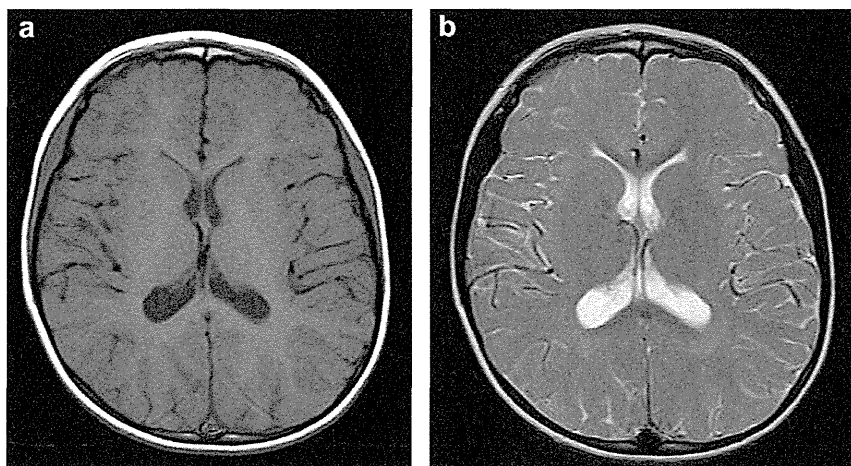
(a) T1-weighted image showing the white matter exhibited higher intensity than the gray matter, but it was still lower than normal. (b) T2-weighted image showing the slightly high intensity in other white matter regions with poor gray and white matter contrast.
